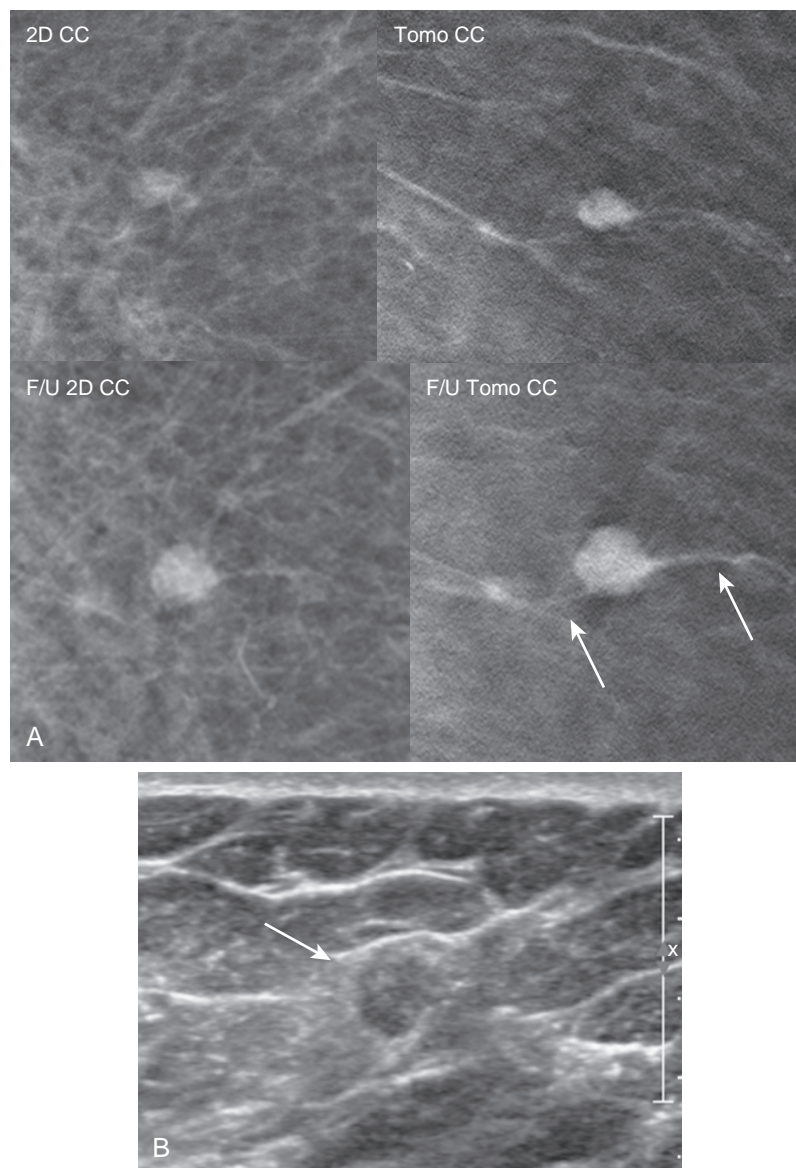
Circumscribed high-grade invasive ductal cancer. (A) Screening mammogram in a 56-year-old woman demonstrates an oval, 5-mm mass in the left breast, with circumscribed margins on tomosynthesis and assessed as BI-RADS 3, probably benign. The mass appeared more prominent and slightly larger at a 6-month follow-up, with subtle lobulated margins and two spiculations (*arrows*). (B) Targeted ultrasound shows a corresponding isoechoic vertically oriented mass (*arrow*) with indistinct margins. Ultrasound-guided core needle biopsy and surgical excision yielded invasive ductal carcinoma, grade 3, ER/PR+, Her2–, 0/1SLN.
